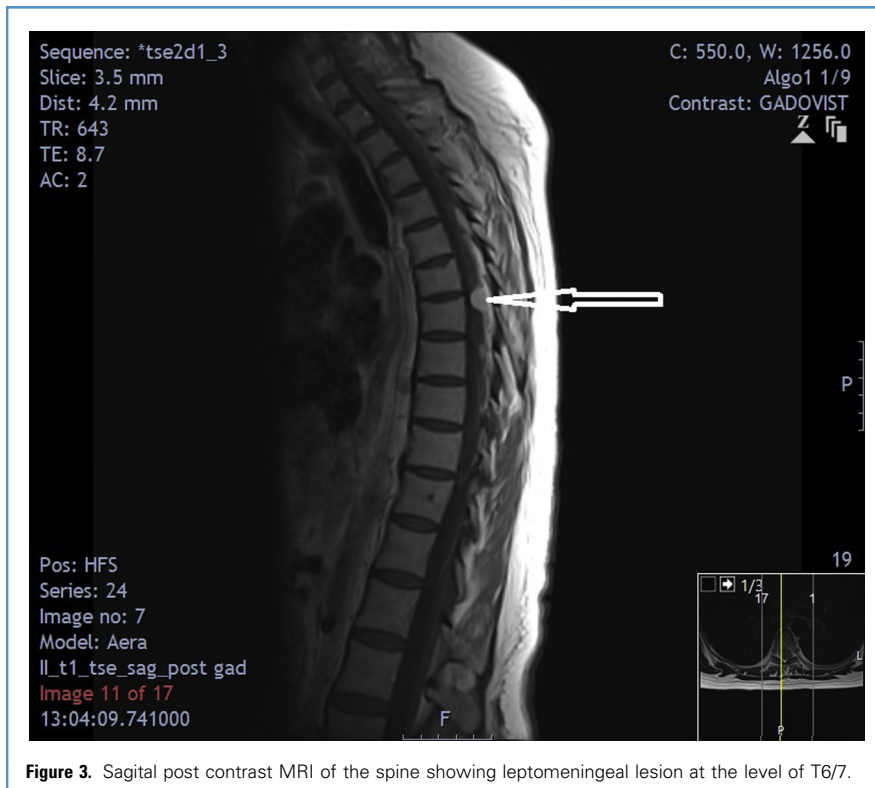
Sagittal post contrast MRI of the spine showing leptomeningeal lesion at the level of T6/7.
